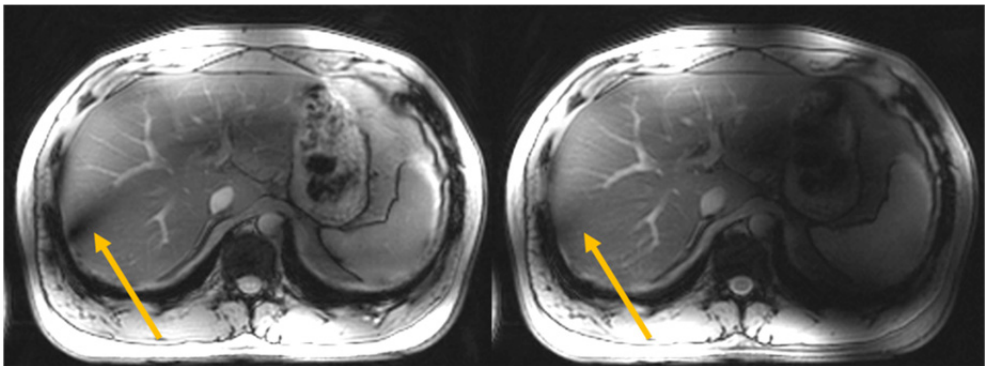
Abdominal T1-weighted FLASH images from a human volunteer. The left image was acquired with a phase increment of 45° between neighboring elements. The right image was acquired with a shim optimized for homogeneity in the right body region. The signal dropout (arrows) is significantly reduced by the dedicated RF shim.
